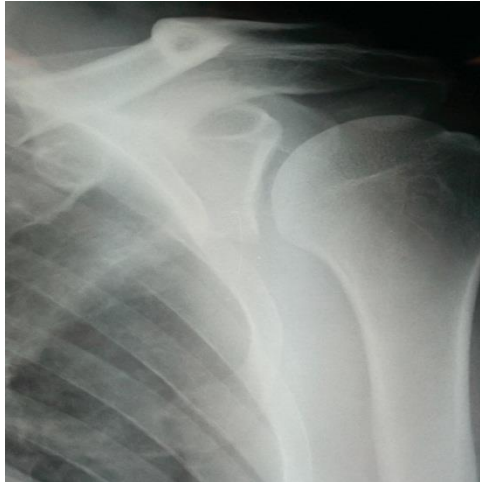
Preoperative shoulder x-ray.
